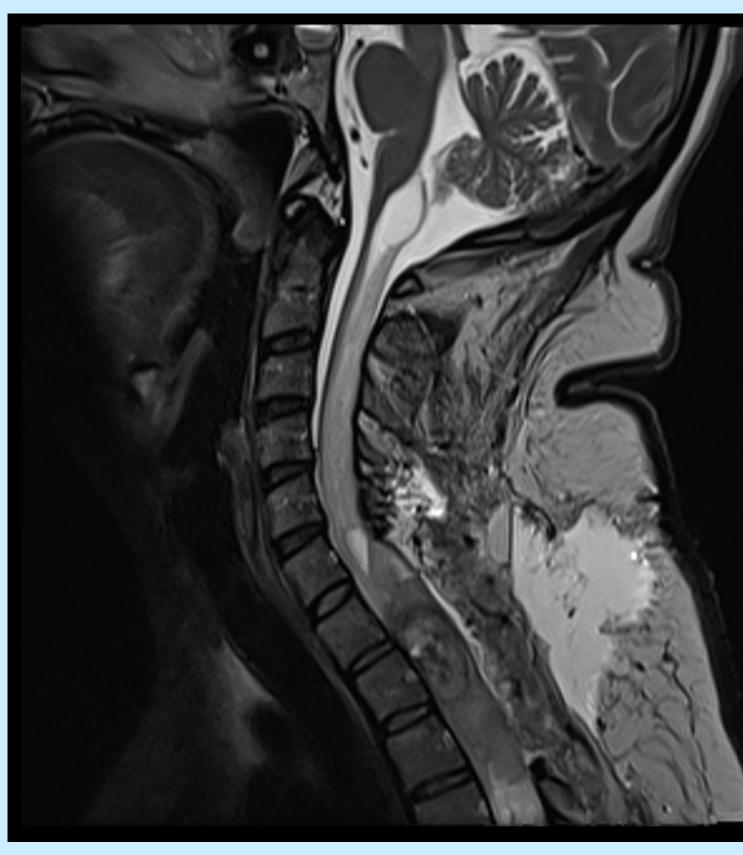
T2-weighted image demonstrating post-operative hematoma spanning from C6-T3.
